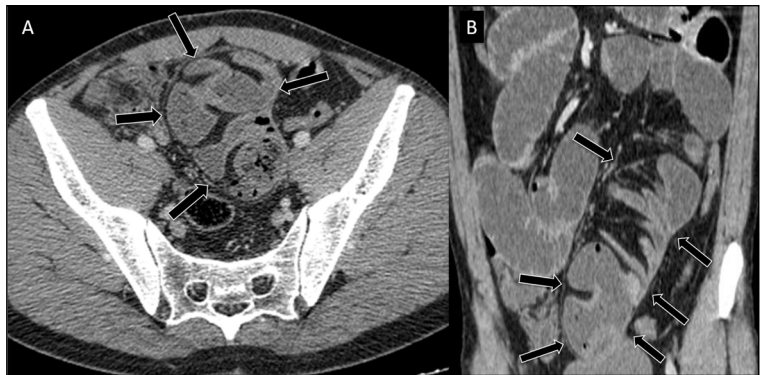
Axial (A) and coronal (B) contrast-enhanced abdominal computed tomography showing clustered small intestines and a thin membranous structure surrounding the intestinal loops (arrows).
